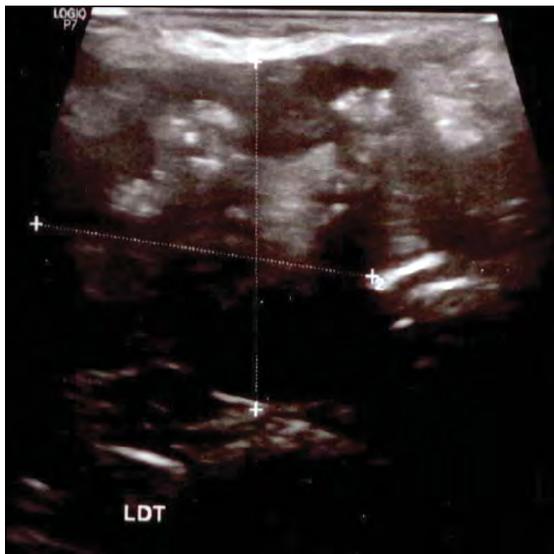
Right lobe at thyroid ultrasound: 3.3 by 3.2 by 4.3 cm (inhomogenous, hypoechoic pattern, poorly shaped aspect)
